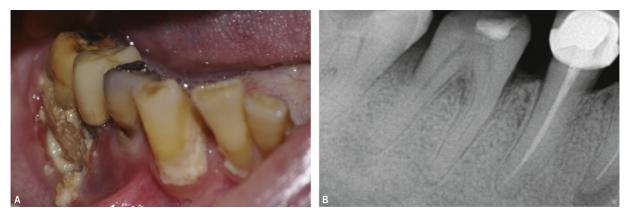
Example of exposed medication-related osteonecrosis of the jaw. A patient receiving high-dose denosumab presented with pain of 6 months' duration on the right lower first molar. He was receiving antibiotics. A, Exposed bone and purulence was observed on the buccal alveolar bone area of the tooth consistent with osteonecrosis of the jaw, exposed type, before dental extraction. B, Panoramic radiography disclosed alveolar bone loss around the molar tooth. (Images courtesy of Professor Ourania Nicolatou-Galitis, Dental School, National and Kapodistrian University of Athens.)
